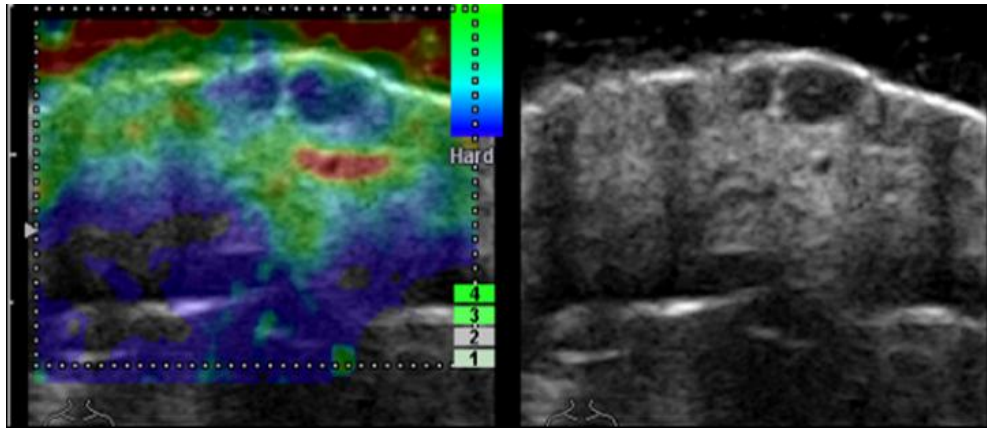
An elastogram (left) and ultrasound image (right) showing squamous cell carcinoma of the skin (Harland et al., 2003).
